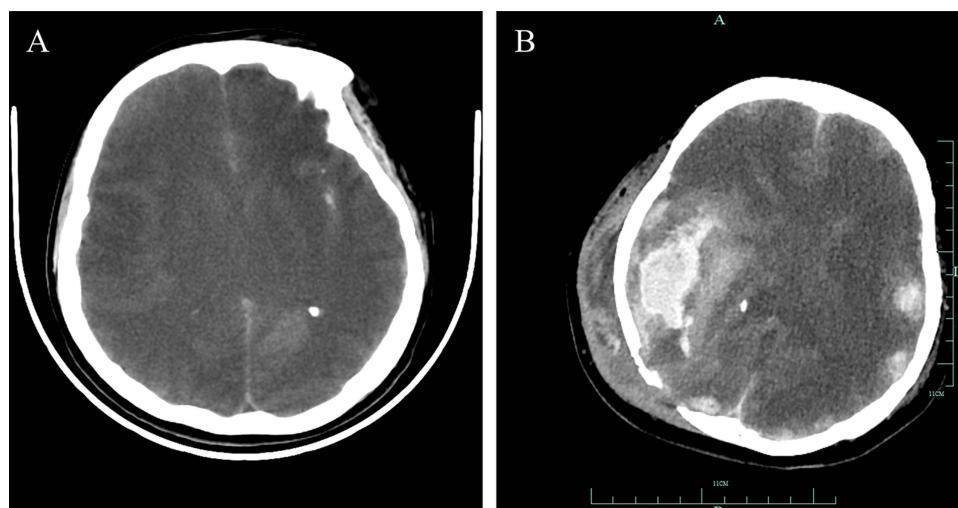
Brain CT images of the patient. (A) Brain CT imaging on October 15, 2019. The head CT imaging was showed diffuse edema of brain tissue, gray matter and white matter structure blurred. (B) Brain CT on September 14, 2022. The brain CT imaging was showed the right temporo-parietal cerebral hemorrhage and occipital defect with subcutaneous abscess.
